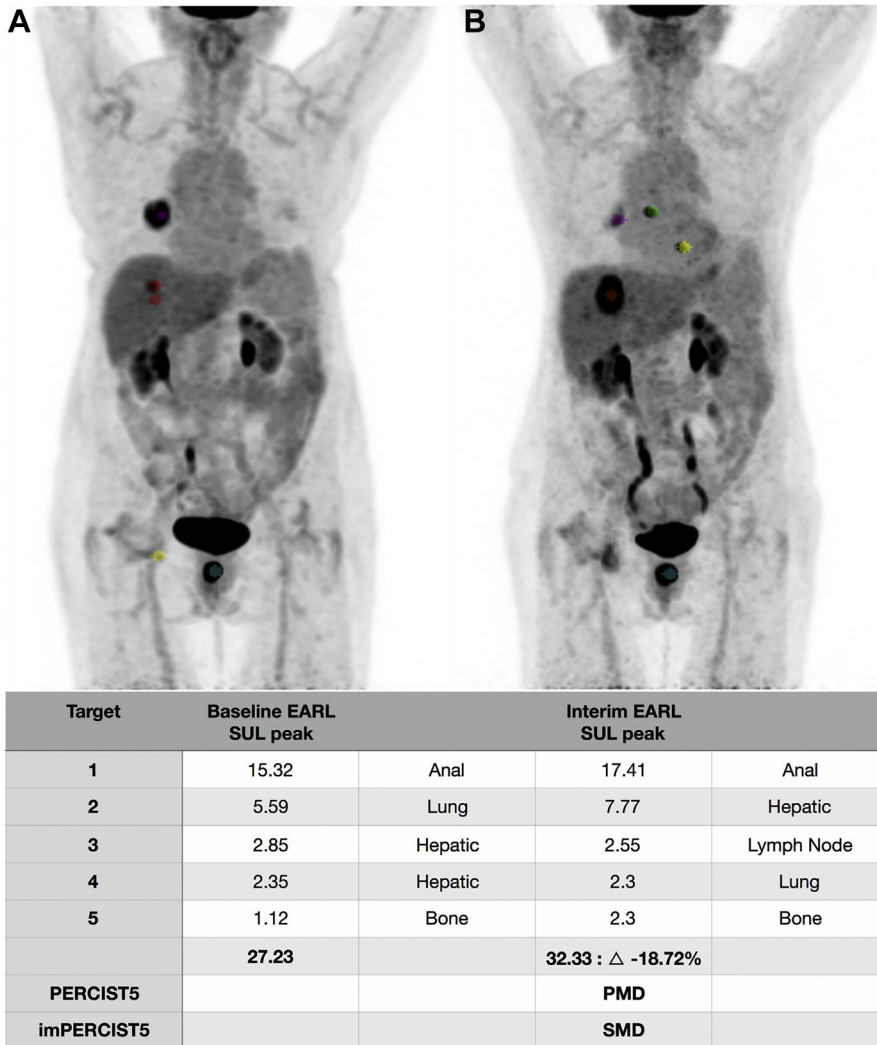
Evaluating tumor response: PERCIST versus immune-adapted PERCIST. Serial ^{18}F FDG MIP in different phases of the disease in a 73-year-old woman affected by a melanoma of the anal canal with lung and lymph node hepatic metastasis. (A) PET baseline before introduction of immunotherapy and (B) after 6 courses of nivolumab, showing the appearance of new lesions. This pattern classifies the patient with PMD according to the PERCIST5 criteria, but stable metabolic disease is found when using imPERCIST5. EARL, EANM Research Ltd; SMD, stable metabolic disease.
